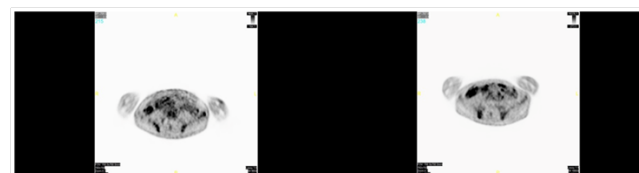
PET/CT of body and extremities showing improvement in hypermetabolic activity in bones of right hemipelvis. Left image (March 2014) shows abnormal activity in right iliac bone with SUV of 3.4g/ml. Right image (May 2014) shows same area 2 months later with less uptake and SUV of 2.9g/ml.
